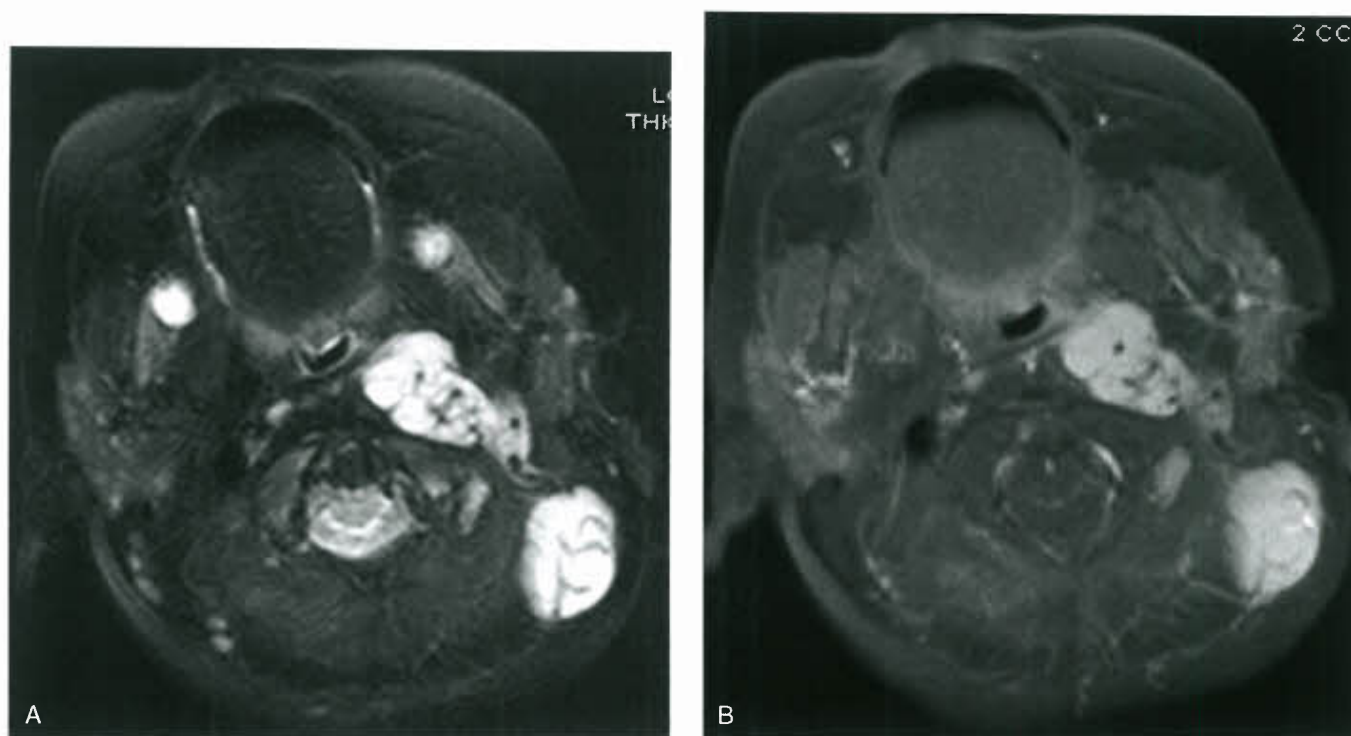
MRI of infantile hemangiomas. Two well-defined, lobulated soft tissue masses in the left occipital and parapharyngeal spaces. Note the hyperintense signal and flow voids (enlarged vessels) on axial T2 sequence (A) and strong enhancement following contrast administration on axial T1 sequence (B).
